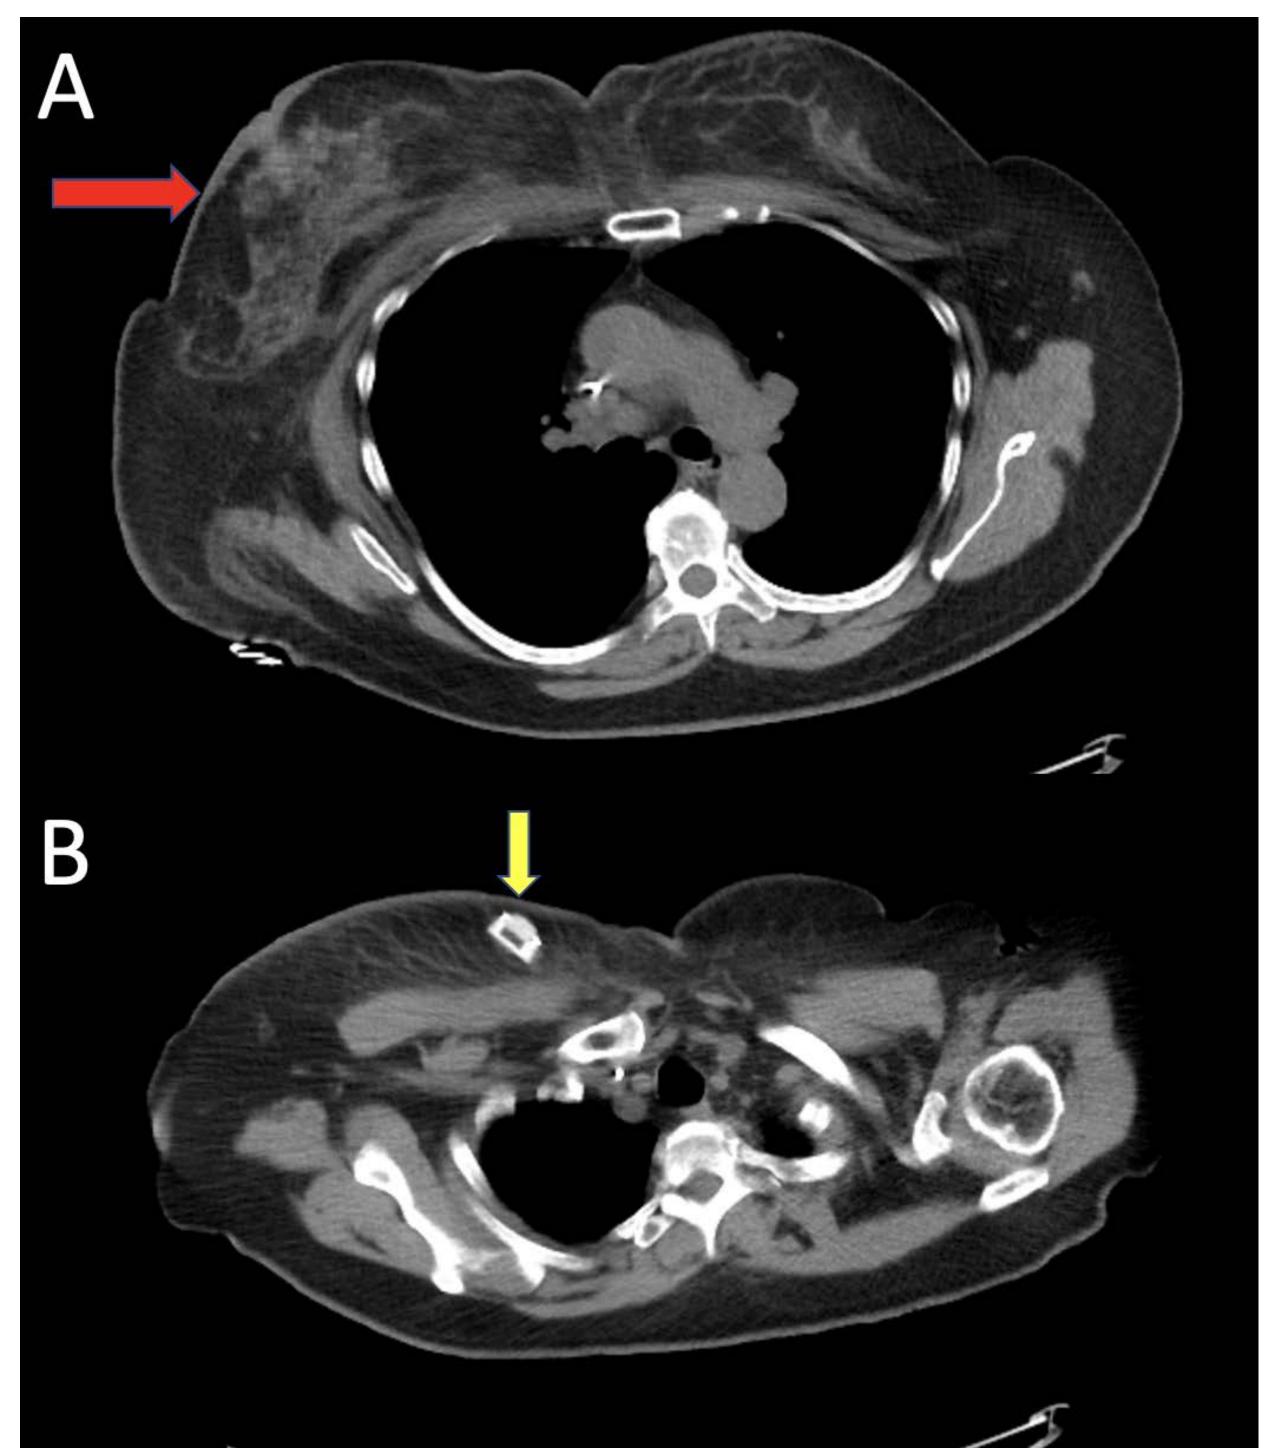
Axial view of the CT scan of the chest showing (A) inflammation (B) the port lying obliquely under the skin (yellow arrow).
